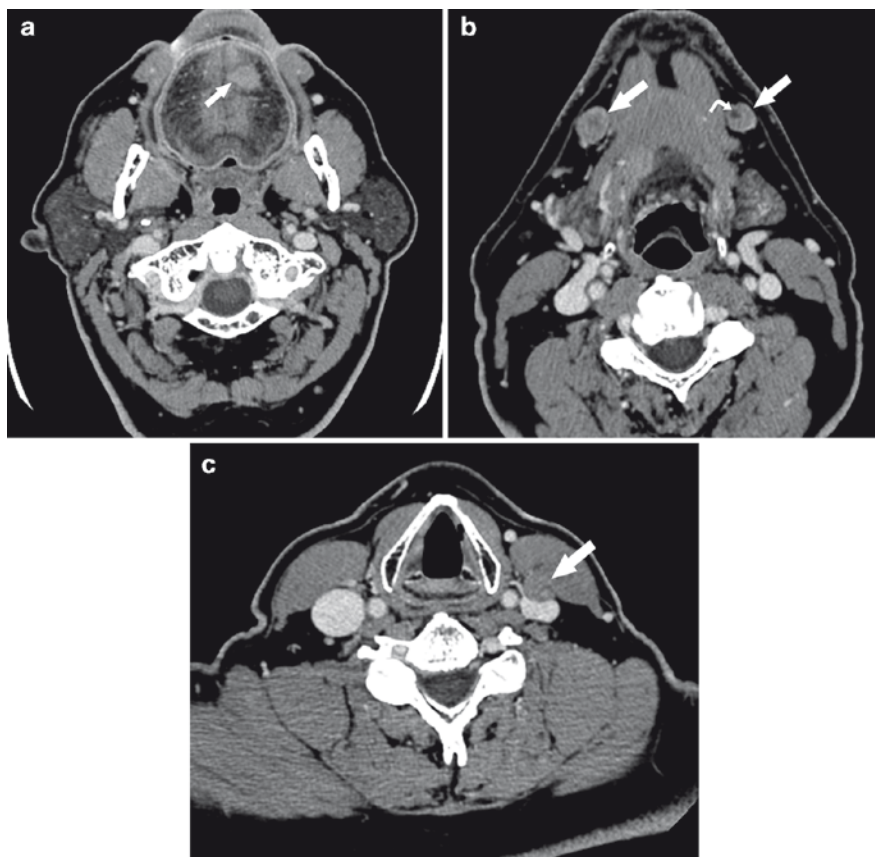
Early-stage oral tongue carcinoma that approaches the midline, with bilateral nodal metastases. (a) Axial CT images shows fairly small left anterior oral tongue primary that reaches the midline (*arrow*). (b) Bilateral level 1b nodal metastases (*straight arrows*), each with internal areas of necrosis, perhaps more obvious on the left side (*curved arrow*). (c) Level 3 nodal metastasis (*arrow*), somewhat inapparent due to similar density compared with adjacent sternocleidomastoid muscle. The node is compressing the anterior surface of the internal jugular vein. Necrosis in this node is difficult to discern
